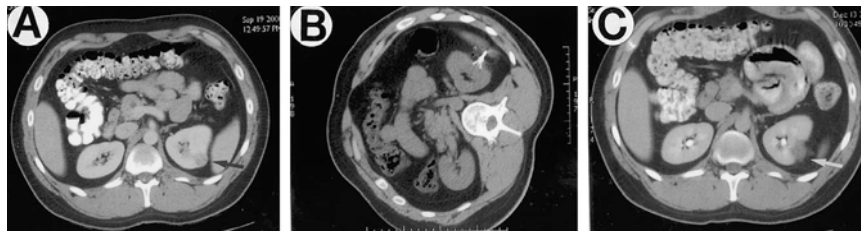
CT before, during and after radio frequency ablation (patient 20, treatment 23). *A*, after contrast CT 1 month before treatment indicates solid enhancing tumor (difference in HU 54) in lateral aspect of left kidney (black arrow). *B*, patient in right lateral decubitus position during treatment and probe electrodes are deployed in tumor. *C*, 2-month followup after contrast CT lesioned area remains visible (white arrow) but no longer enhances (difference in HU 4).
